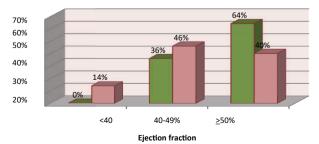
Distribution of study population according to Echocardiographic findings (n=100).
